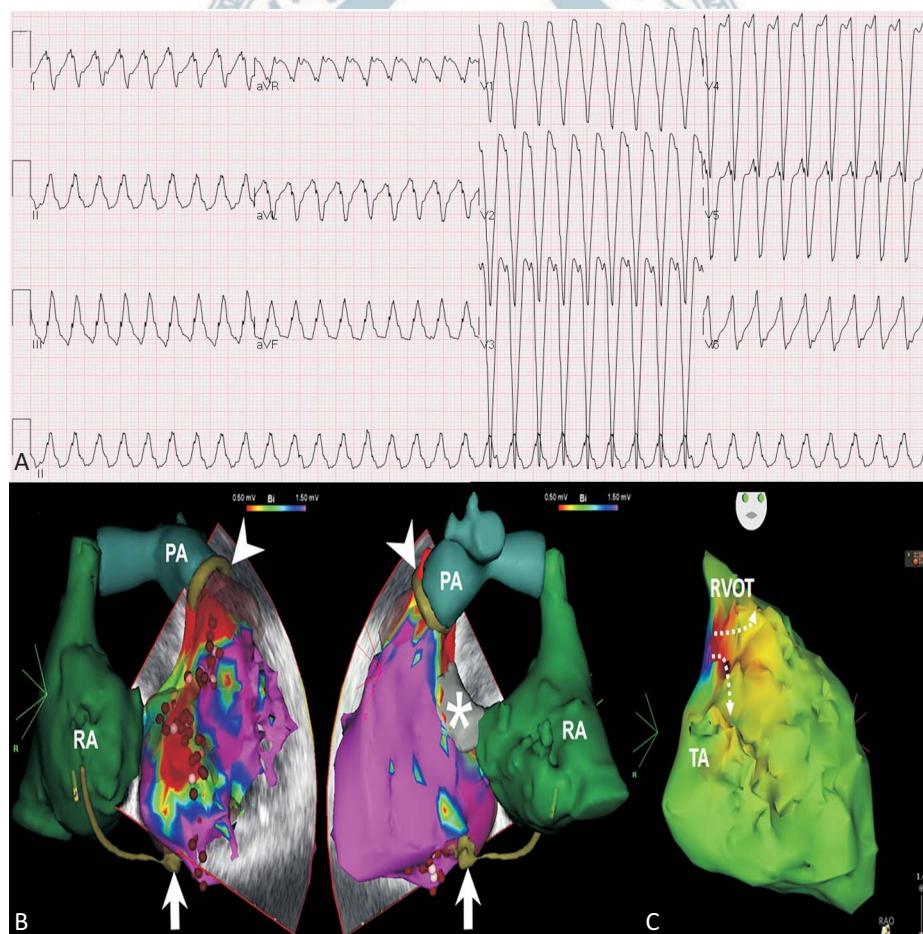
Clinical sustained monomorphic VT with features of left bundle branch block and inferior axis (A). The electroanatomic map of right ventricle created by CartoSound system and Thermocool catheter was merged with the three-dimensional reconstruction of ventricular septal defect (VSD) patch (asterisk), tissue pulmonary valve (arrow head), and epicardial lead (arrow) from computed tomography images (B). The activation map of clinical VT demonstrated that the VT isthmus was located between the free wall of RVOT and tricuspid annulus (C). PA, pulmonary artery; RA, right atrium; RVOT, right ventricular outflow tract; TA, tricuspid annulus; VT, ventricular tachycardia.
